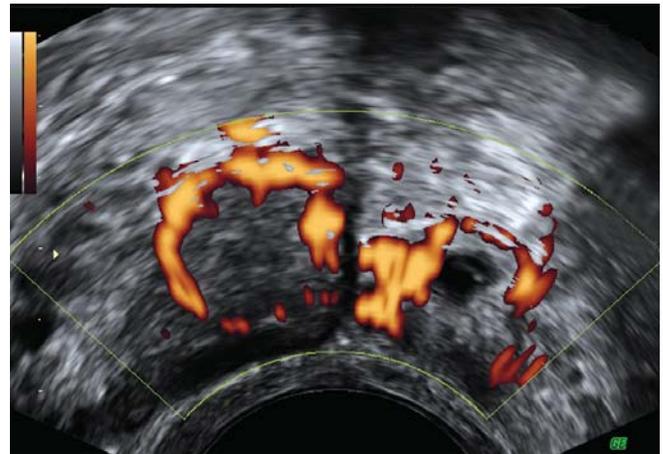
Ectopic blighted ovum pregnancy with corpus luteum in power Doppler mode. Nonviability with low serum beta HCG made methotrexate first choice- therapy
